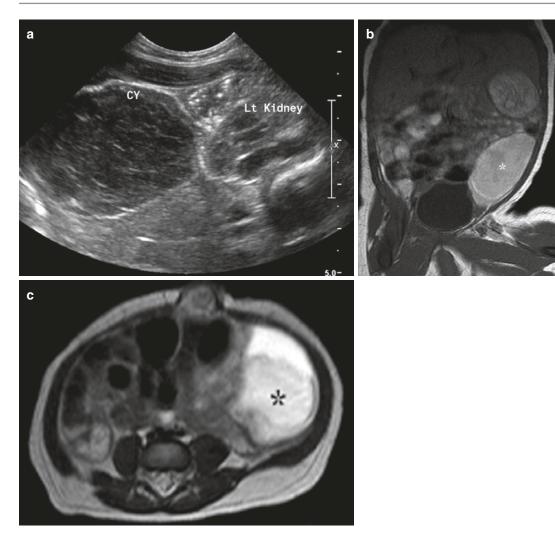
Torsion of ovarian cyst. US image (a) (annotated) in a 4 day old female with an antenatal abdominal mass, shows a complex mass in the left flank (cy), inferior to the lower pole of the kidney, which has cystic and solid components. Coronal and axial MR images (b and c)
